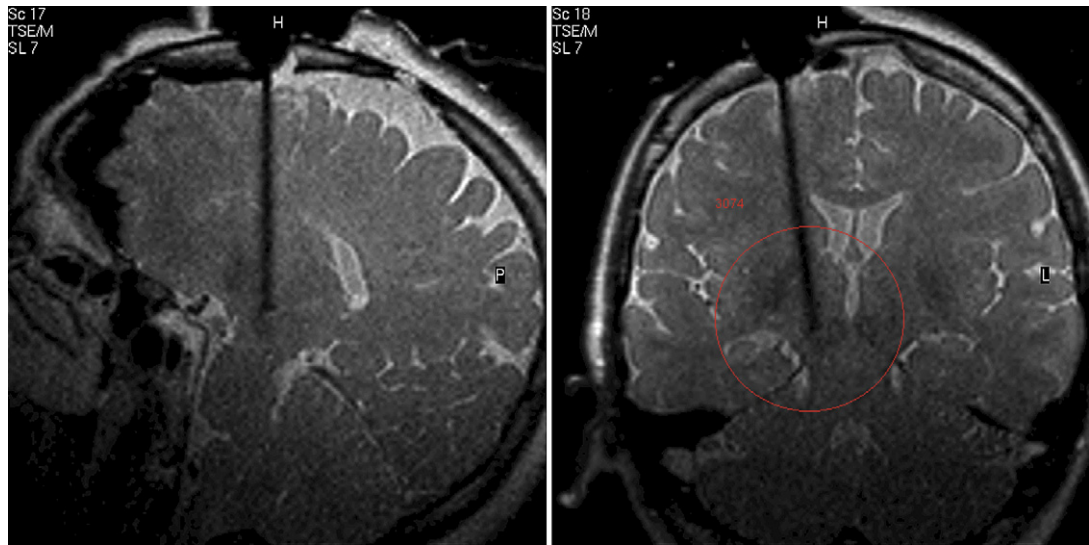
Intraoperative MR images during an iMRI DBS case. Images obtained at 90° to each other in plane with the target trajectory show a ceramic stylet and peel-away sheath that has been placed in the right STN.
